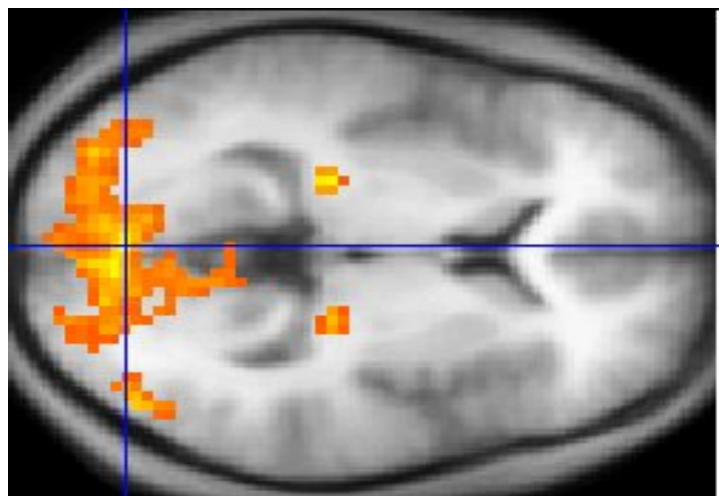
Functional magnetic resonance imaging
